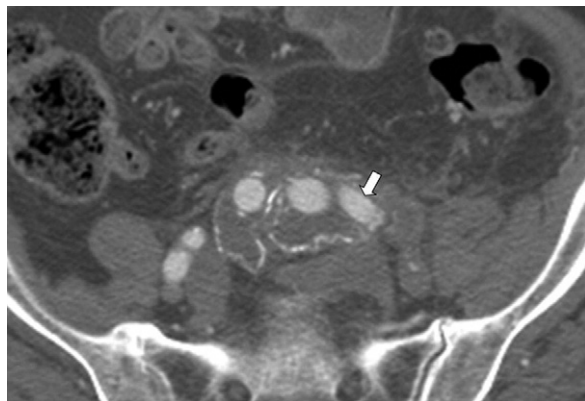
A postoperative computed tomography scan at 10 months shows the patent left hypogastric artery bypass graft (*arrow*).
